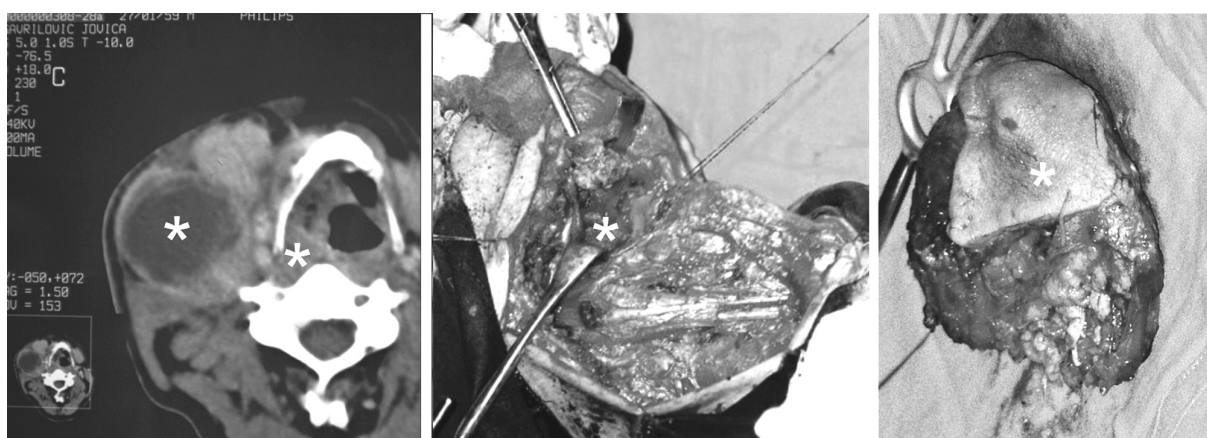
Hypopharyngeal carcinoma with cervical metastasis: CT, intraoperative view, excised tumor.
